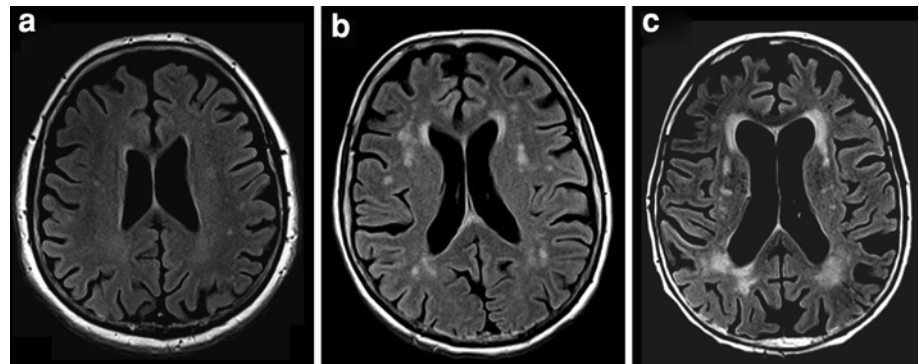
Periventricular signal hyperintensities as seen on FLAIR-weighted MRI scans of the brain in axial orientation at 3T. Arrows in enlarged insets show caps (a 77-year-old female), pencil-thin lining (b 76-year-old male), and halo (c 56-year-old female)
